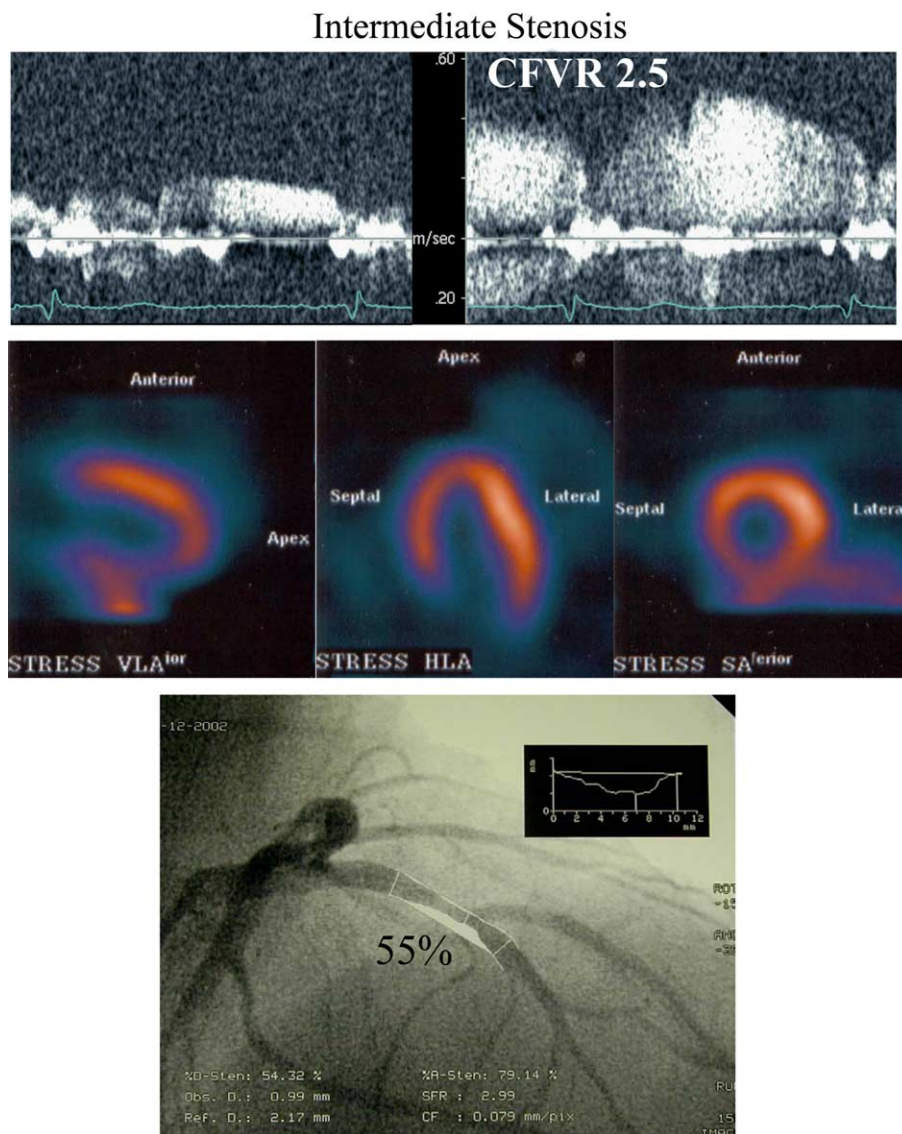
Transthoracic coronary Doppler ultrasound helps evaluating the physiological impact of intermediate coronary stenoses. In this case, a good CFVR is in accordance with myocardial scintigraphy, showing no perfusion defects at stress.
